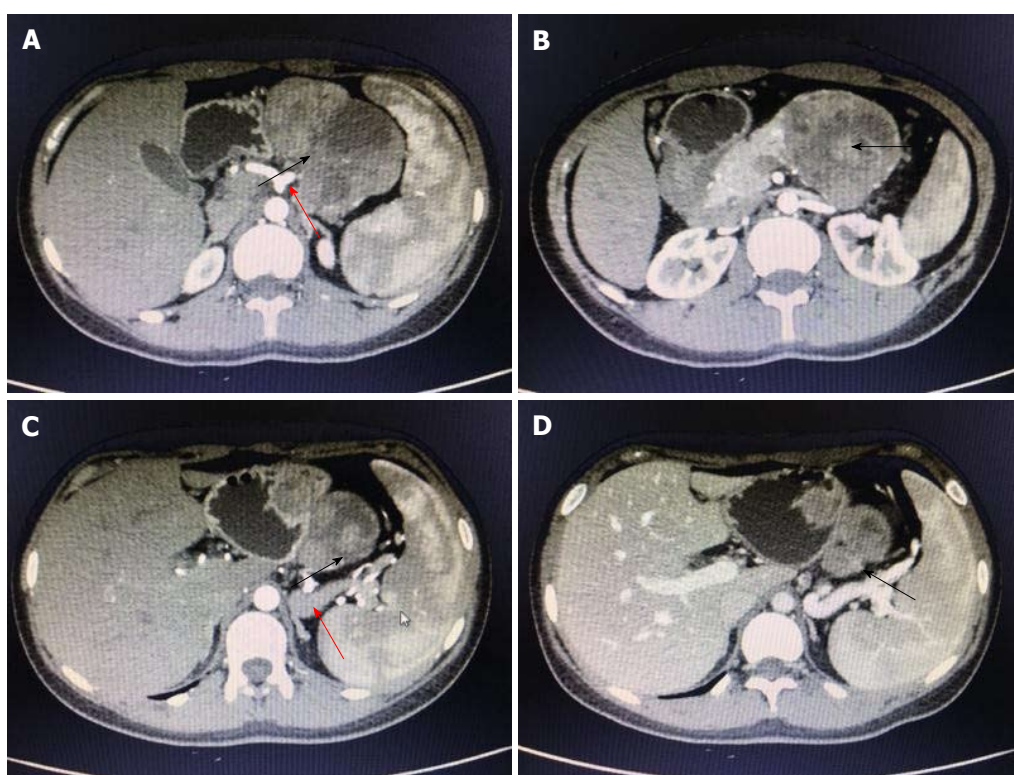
Findings of contrast-enhanced abdominal computed tomography scan. A and B: Contrast-enhanced abdominal computed tomography reveals a mixed density mass with solid and cystic components, sized 6.8 cm × 7.8 cm × 8.8 cm, in the body and tail of the pancreas, with a well-defined border. Nodular calcifications are found inside the lesion; C: The solid component is obviously enhanced, although the degree of enhancement is lower than the normal pancreatic parenchyma; D: The spleen is slightly larger, and the splenic vein is compressed. Multiple collateral circulations are seen in the left upper abdomen. The lesion is fed by the common hepatic artery and a branch of splenic artery (red arrows in A and C, black arrows indicate the mass).
